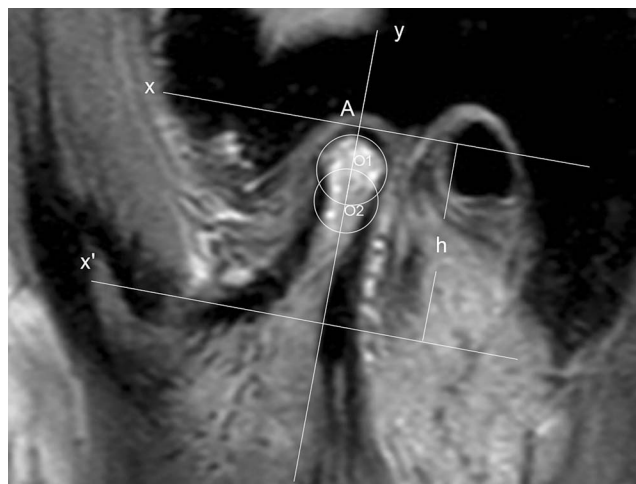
Measurements of condylar height in MRI images.
